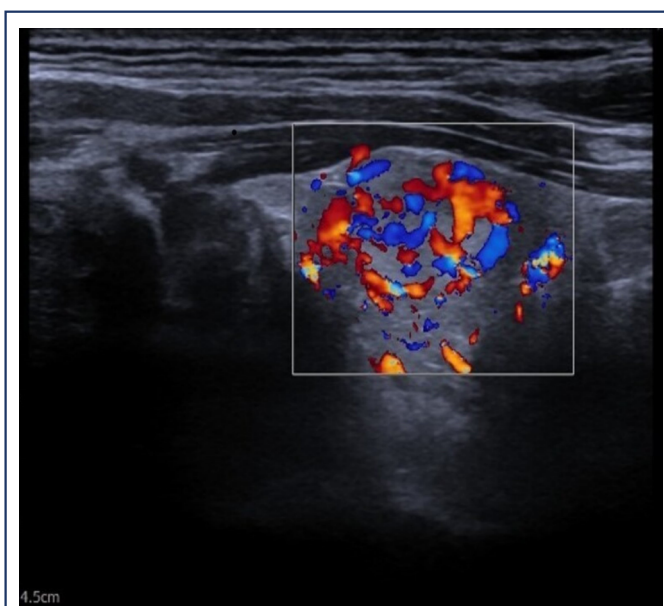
Color Doppler ultrasound image showing (++) vascularization. Color Doppler ultrasound image showing (++) vascularization. Peripheral vascular blood supply in 56-year-old female, biopsy yielded Bethesda 2 findings
